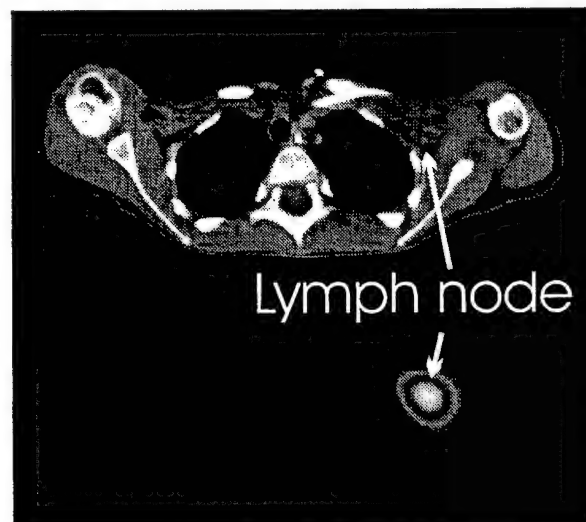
Correlated X-ray CT and  $^{131}\text{I}$ -MIBG tomographic images of a neuroblastoma patient.
